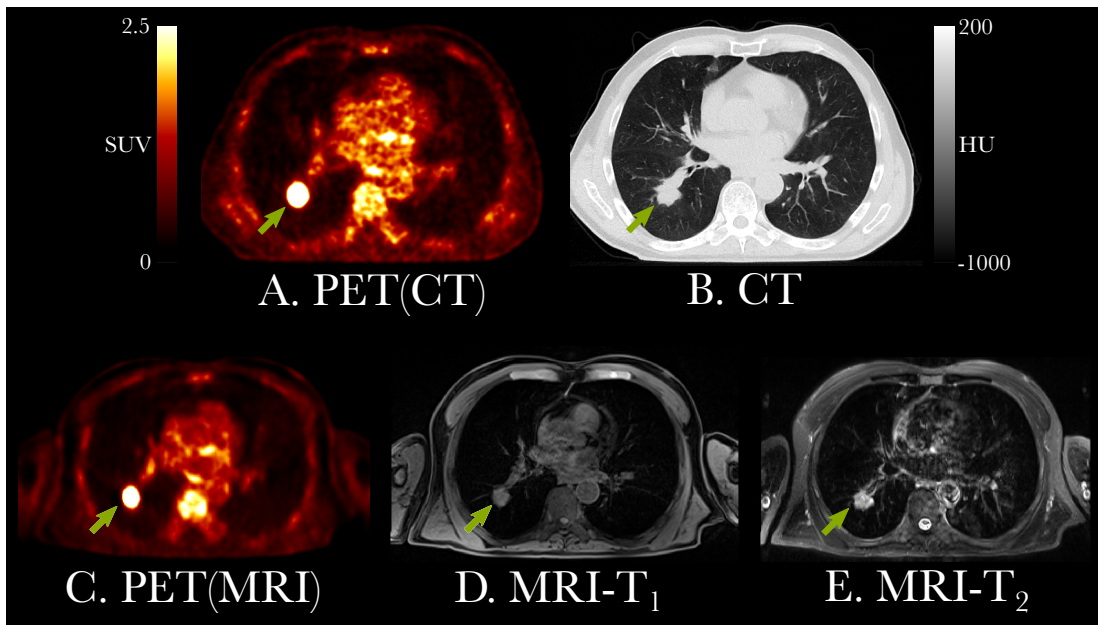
PET/CT (top row) and PET/MRI (bottom row) scans of a patient with non-small-cell lung cancer using the ^{18}F -FDG tracer. A. PET from the PET/CT scan. B. CT. C. PET from the PET/MRI scan. D. T_1 -weighted MRI. E. T_2 -weighted MRI. The PET/CT scan was performed 60 minutes post-injection of ^{18}F -FDG, while PET/MRI started 120 minutes after injection. Geometrical differences between PET/CT and PET/MRI are attributed to arms-up protocol for PET/CT and arms-down protocol for PET/MRI. The lung tumor is indicated with green arrow in each image.
